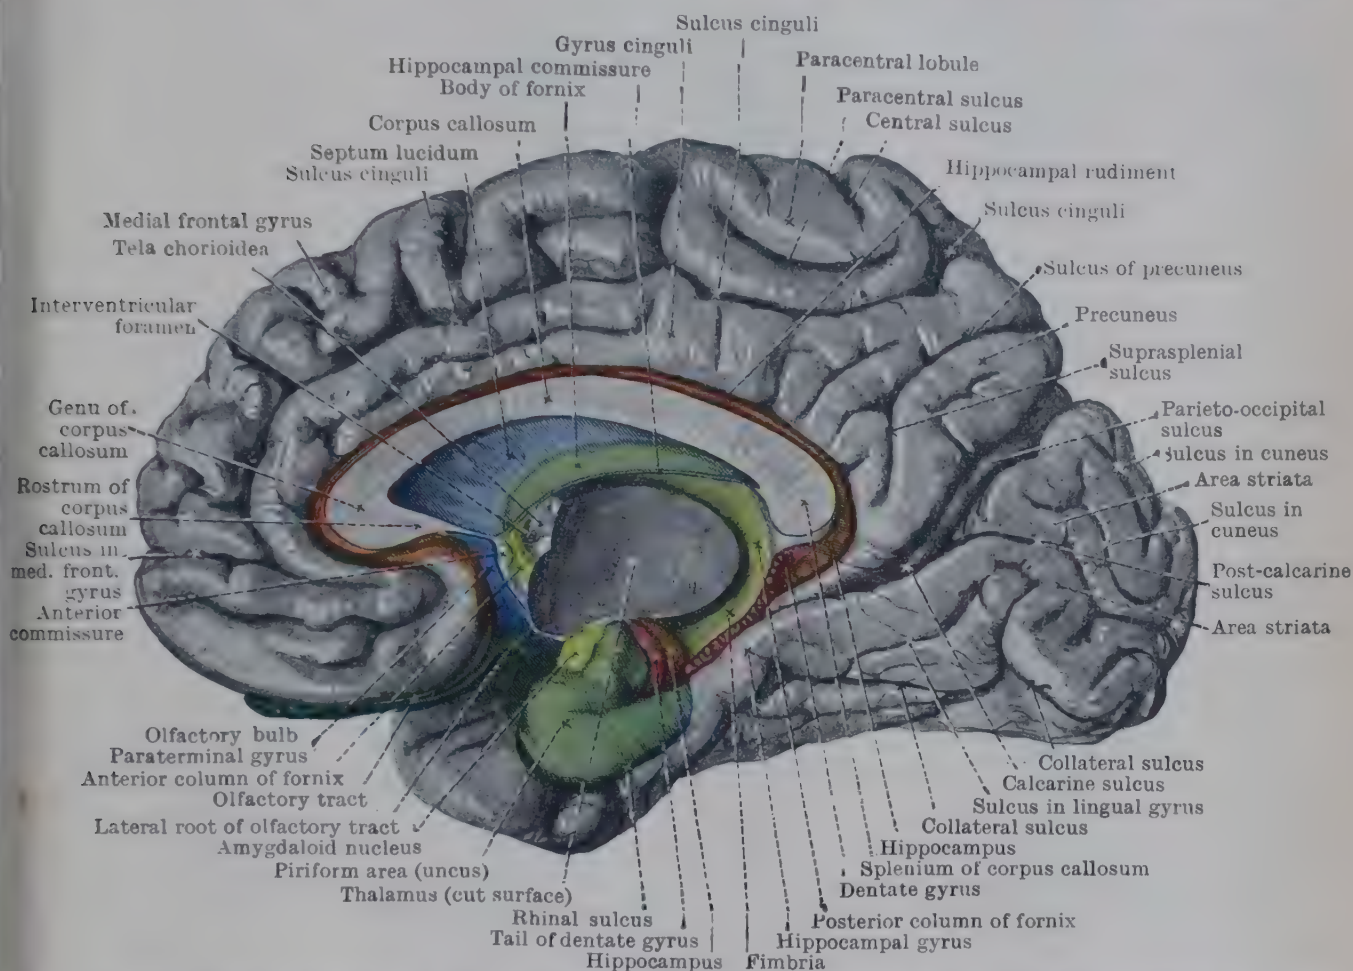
MEDIAL ASPECT OF RIGHT CEREBRAL HEMISPHERE, WITH THE MAIN OLFACTORY CENTRES ON THE BASE OF THE BRAIN COLOURED GREEN.
